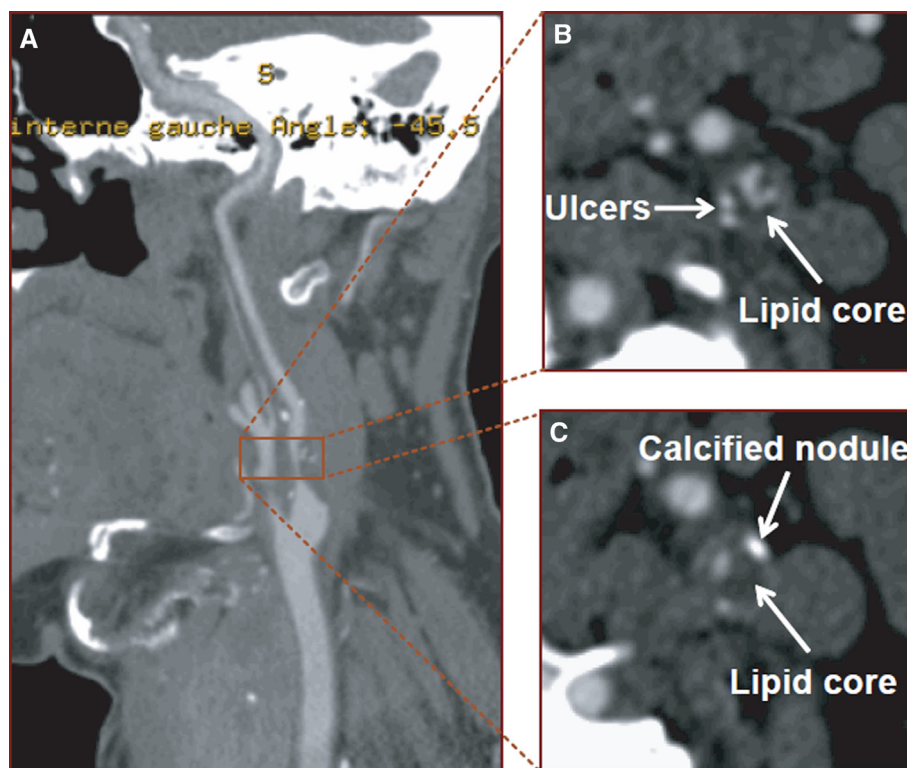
Multidetector computed tomography angiography of the neck of a patient with left-sided amaurosis fugax. (A) Sagittal reconstruction of the carotid artery lumen, showing severe left internal carotid artery stenosis and ulcerations. Cross-sectional images from the superior (B) and inferior (C) cuts of the region of interest in (A). (B) The plaque contains a lipid core (hypodense posterior vessel wall) and is ulcerated because contrast has extravasated posteromedially (arrow pointing to “ulcers”). (C) Inferiorly, the lipid core is larger, and there is a calcified nodule in the anterior vessel wall. This figure is available in colour online at <http://carjonline.org/>.
